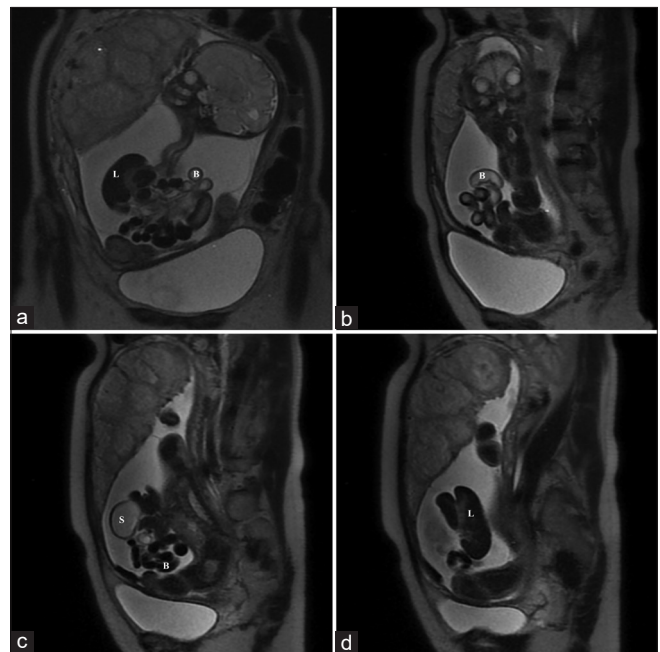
(a-d) Antenatal magnetic resonance imaging showing anterior abdominal wall defect with herniation of bowel loops (B), stomach (S), and liver (L) through the defect. The herniated contents are freely floating in the amniotic fluid and are not covered by any membrane
